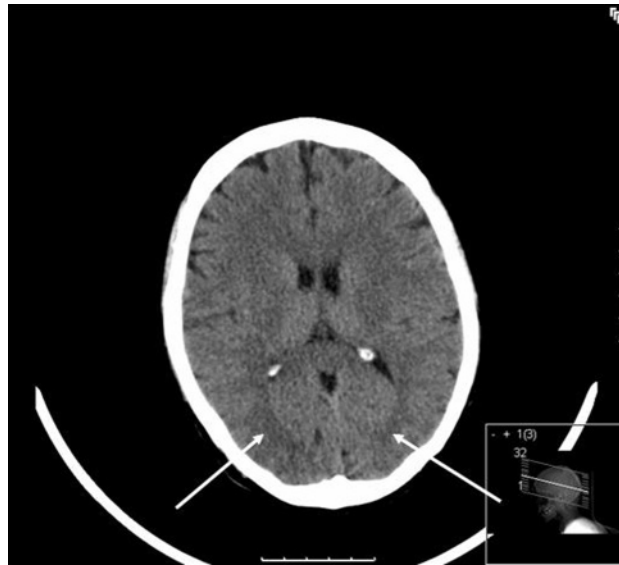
CT scan showing brain stem swelling (arrows). Patients with acute hepatic necrosis are susceptible to brain stem swelling [11] due to breakdown of the endothelial integrity of the blood–brain barrier. Cerebral white matter oedema due to increased endothelial permeability in the subtentorial compartment is termed posterior encephalopathy.
